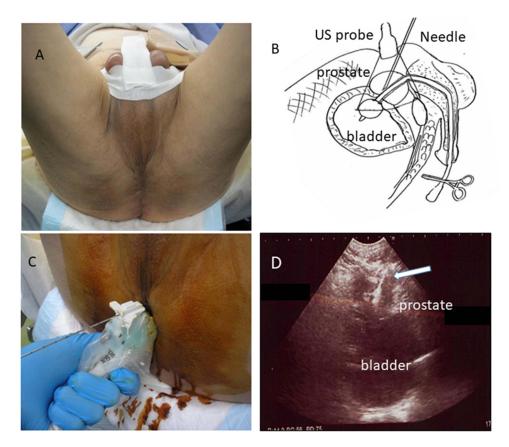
Figure I Cognitive MRI–US fusion transperineal prostate biopsy. (A) The scrotum was extracted anteriorly to expose the perineum. (B) A urethral catheter was inserted, and the catheter balloon was inflated with 10 mL of distilled water. The catheter was clamped after injection of 250 mL of sterile saline to improve visualization of the prostate. Gentle traction was applied to the catheter, and the catheter balloon was advanced to the level of the bladder neck to identify the base of the prostate. (C). The US probe was placed sagittally on the anal dimple and provided clear images of the prostate, urethra, and bladder neck. (D) Cognitive MRI–US fusion transperineal prostate biopsy was performed using a 25° angle of approach in conjunction with a nephrostomy grid. An 18-gauge biopsy needle (white arrow) was directed to the target area by visual registration through the nephrostomy grid.
